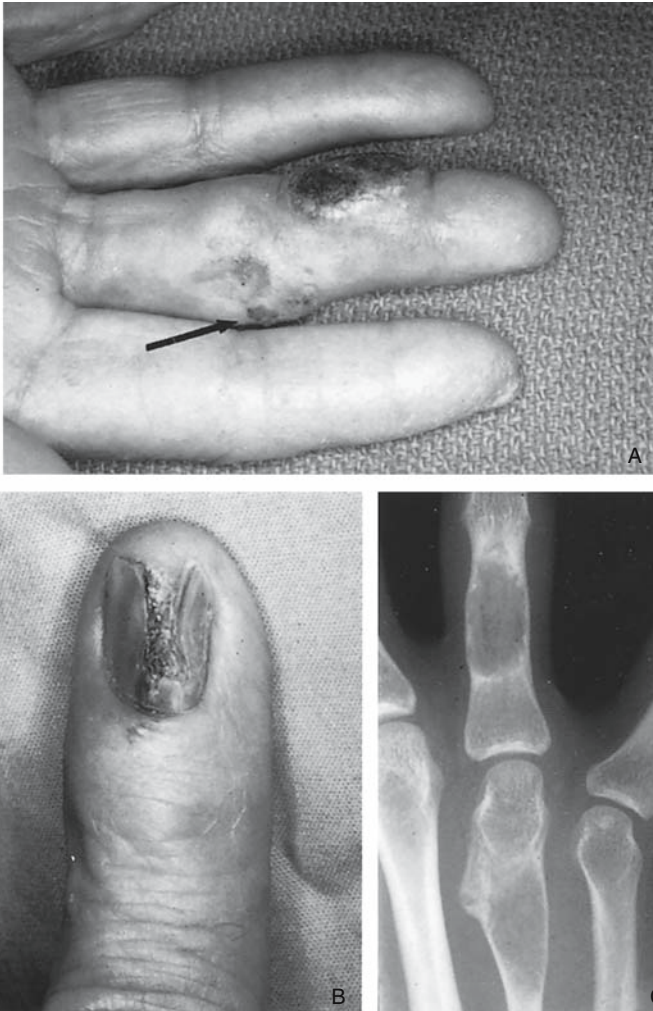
Neoplasms of the hand. (A) Squamous cell carcinoma of finger in patient with 30-year history of holding children being radiographed. Note atrophic skin changes (*arrow*) from the radiation exposure. (B) Subungual melanoma with splitting of the nail from involvement of nail bed. (C) Enchondroma of proximal phalanx with expansion of the diaphysis. Note the enchondroma of the metacarpal with callus from a healed pathologic fracture.
